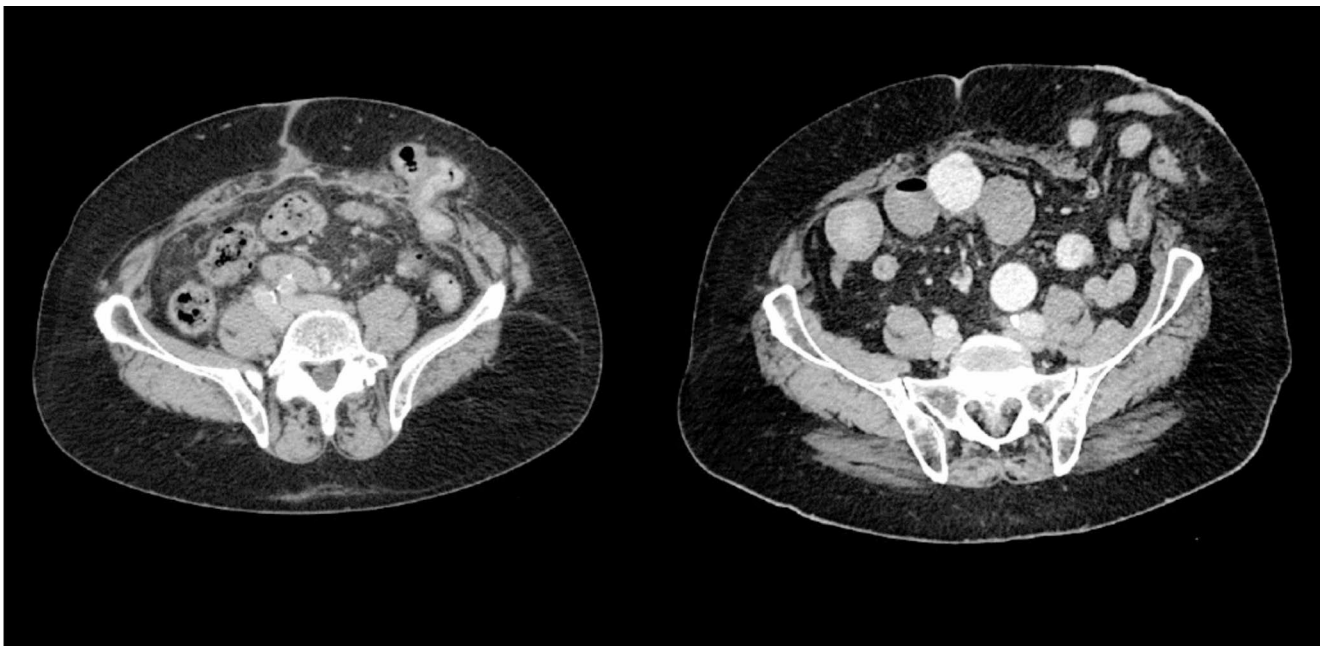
CT scan image showed insufficient lateralization at the 4th postoperative month, which later resulted in a recurrence at 1-year follow-up
